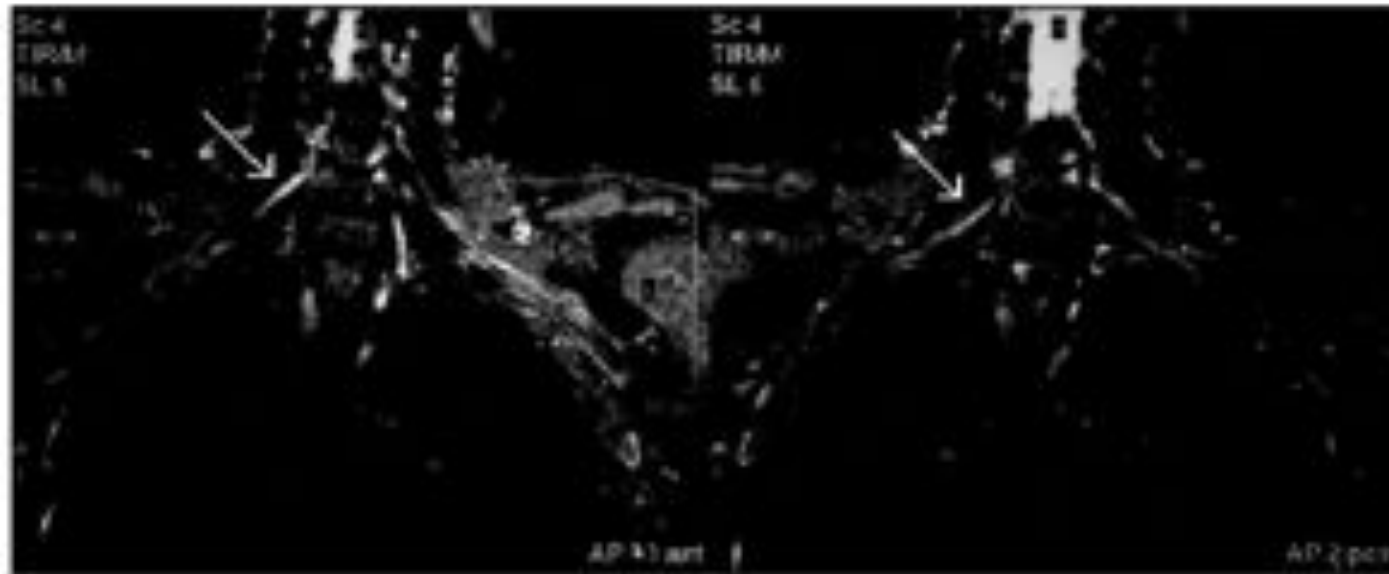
T₂-weighted non-contrast MRI scan of the brachial plexus, showing a thickened and slightly hyperintense middle trunk on the right.
